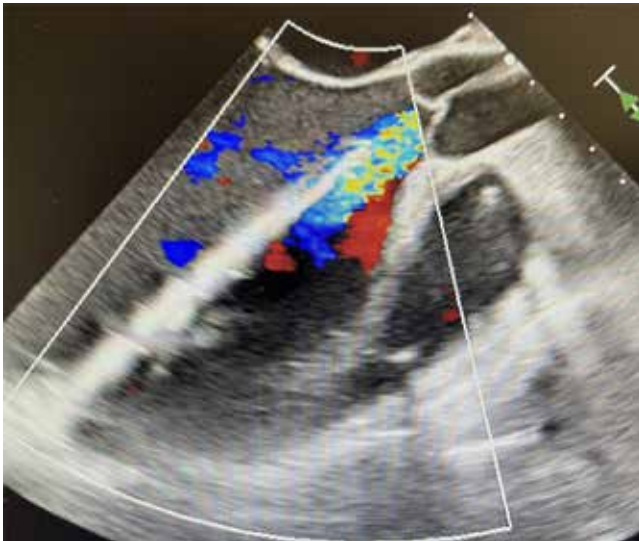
Doppler color imaging of drainage orifices beneath the aortic valve.
